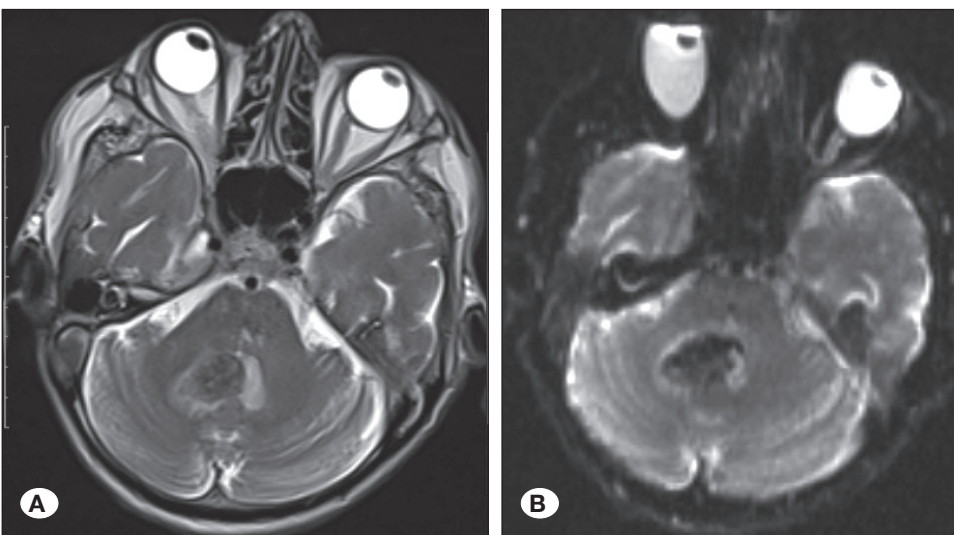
MRI from "Case 4", performed after presentation with SAH, showing a hematoma filling the fourth ventricle and relating to a vascular proliferative lesion in the right cerebellum; A) Axial T2-weighted MRI. B) Axial diffusion ADC MRI.
